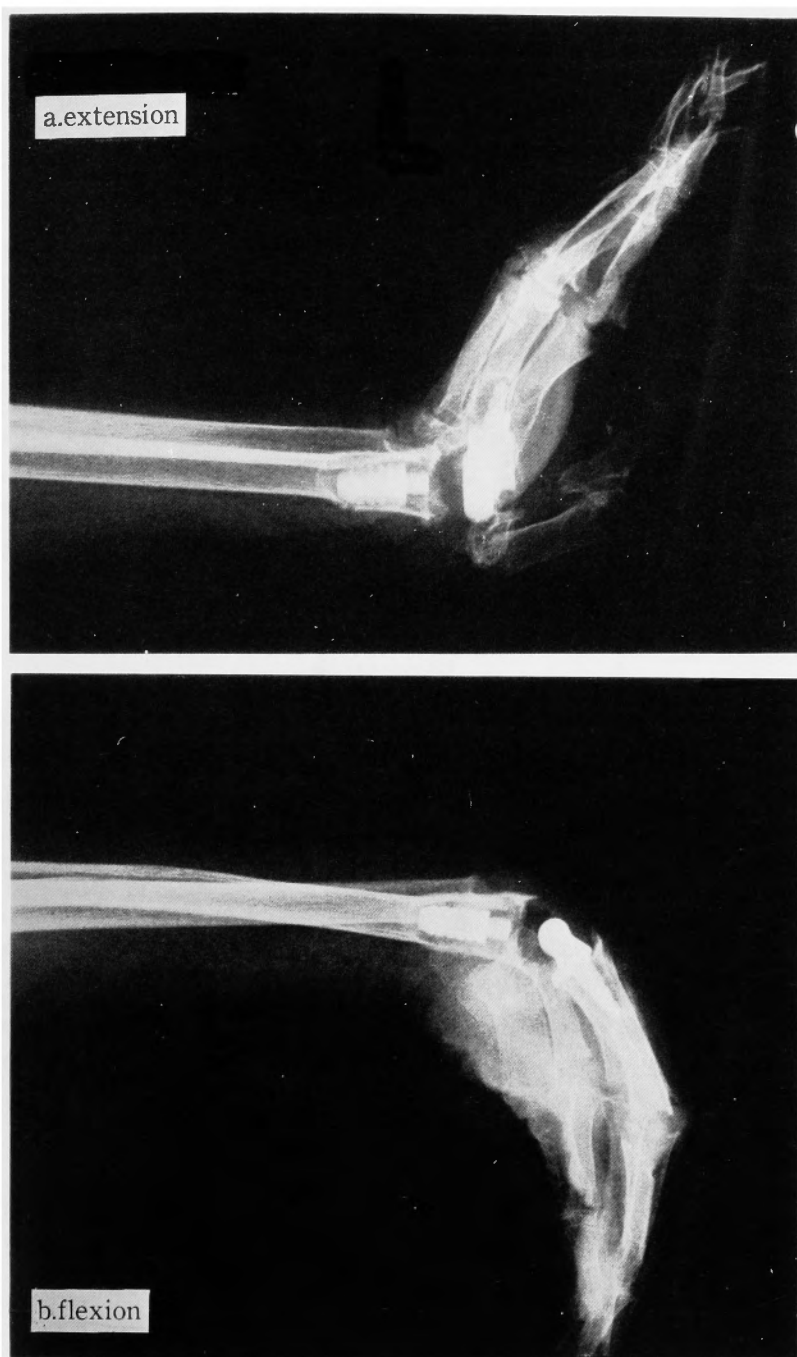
Postoperative lateral radiographs showing good flexion-extension motion of the wrist. The articular portion of the distal component rotating on the shelf of the proximal component.
